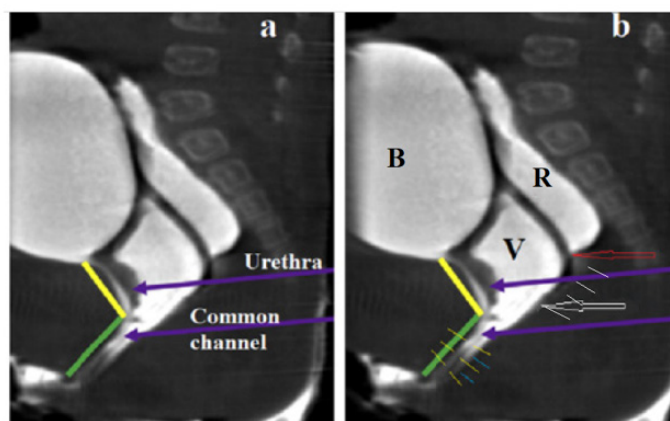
(a) MRI study from the article by Wood et al.,³⁵ with the caption “Short common channel cloaca with adequate urethra.” The authors suggest that, in the angle between the yellow and green lines, the urethra merges with the vagina to form a common channel. In the copy of the same image (b) between the yellow lines, you can see the continuation of the urethra up to the perineum, and next to it, the blue lines indicate the narrow vaginal canal. Between them, a dark dividing line can be observed, representing the fusion of the walls of the urethra and vagina. The upper part of the vagina (V) is dilated (hydrocolpos). The red arrow points to a rectum above the contracted anal canal, which is shown with white lines. It is visible between the red and white arrows. The site of IAS penetration into the vagina divides the vagina into an upper, widened part and a lower, narrow part.
